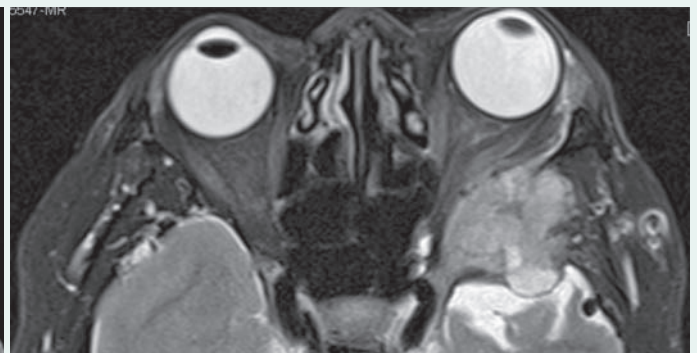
MRI showing location of meningioma invading the orbit.
